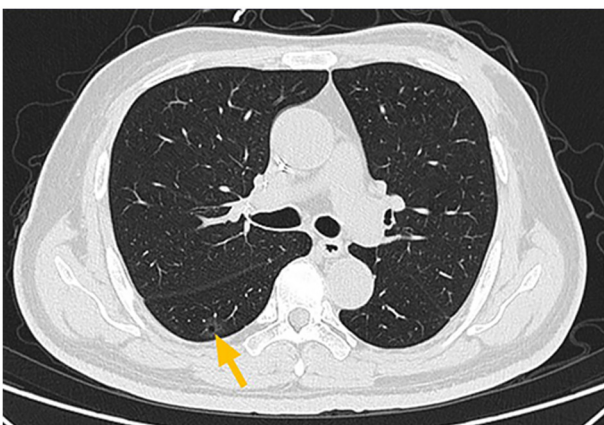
Post-chemotherapy computed tomography image (October 2023) showing stable lung nodule (yellow arrow).
